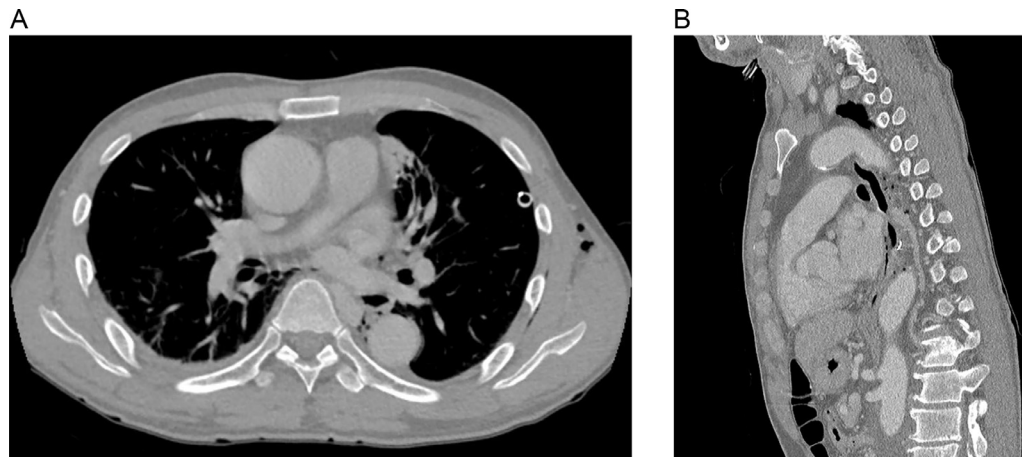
(A) Postoperative delayed contrast-enhanced axial CT scan showing a soft tissue lesion in the posterior mediastinum. (B) Postoperative delayed contrast-enhanced sagittal CT scan. A focal aneurysm of the hemiazygos vein was confirmed through enhancement by contrast agent and was connected to the adjacent hemiazygos vein.
